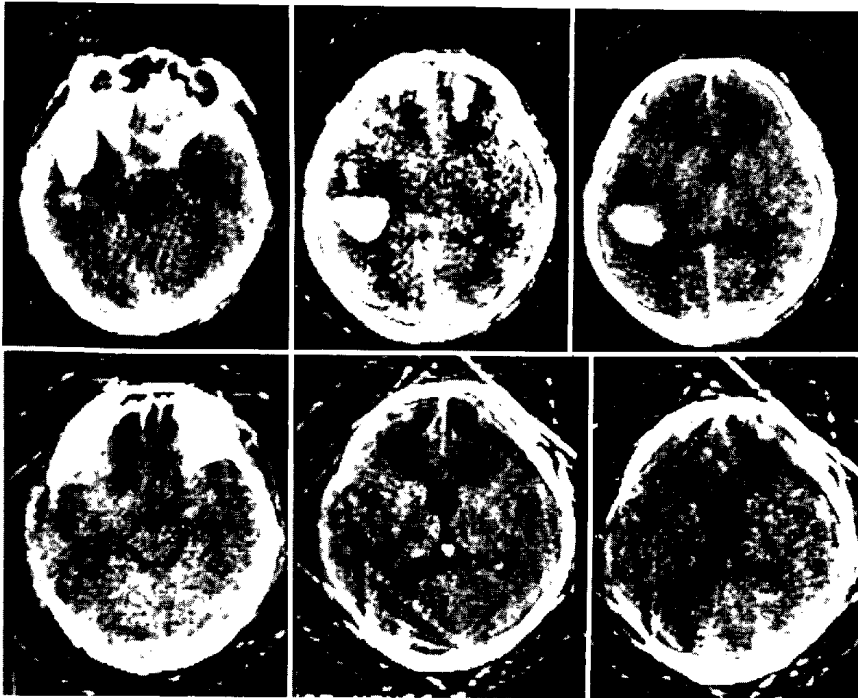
Intracerebral hematoma. 49-year-old male. Three intracerebral hematomas, in the left temporal lobe and both frontal lobes are shown by CT, performed 3 days after trauma (upper). An operation was carried out immediately after the first CT examination and the hematoma was evacuated from the left temporal lobe. CT, performed 10 days after the operation, shows lesions visible as low density areas (lower).
